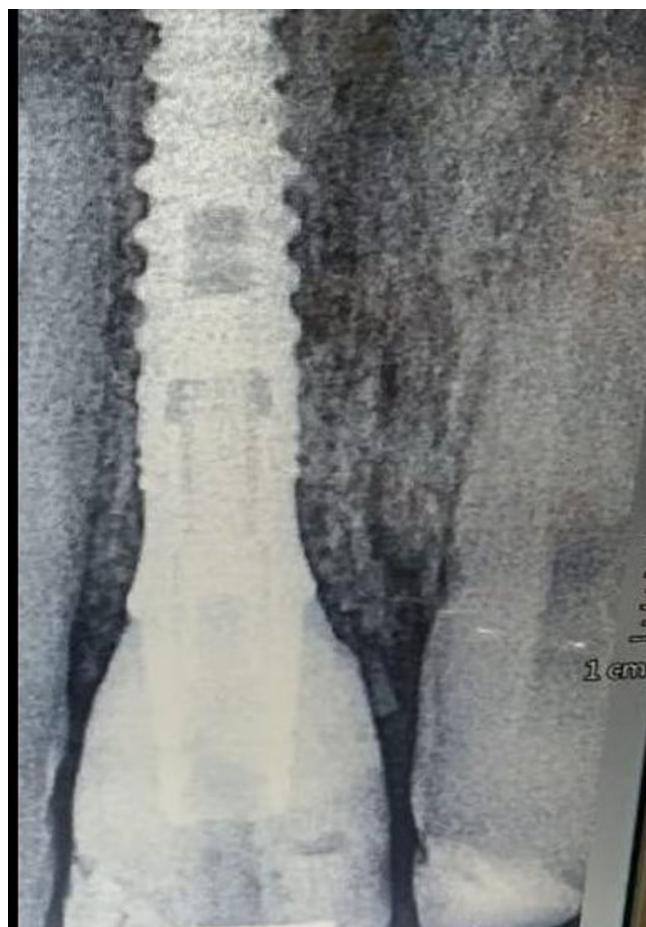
Post operative IOPA radiograph at four year follow up.
